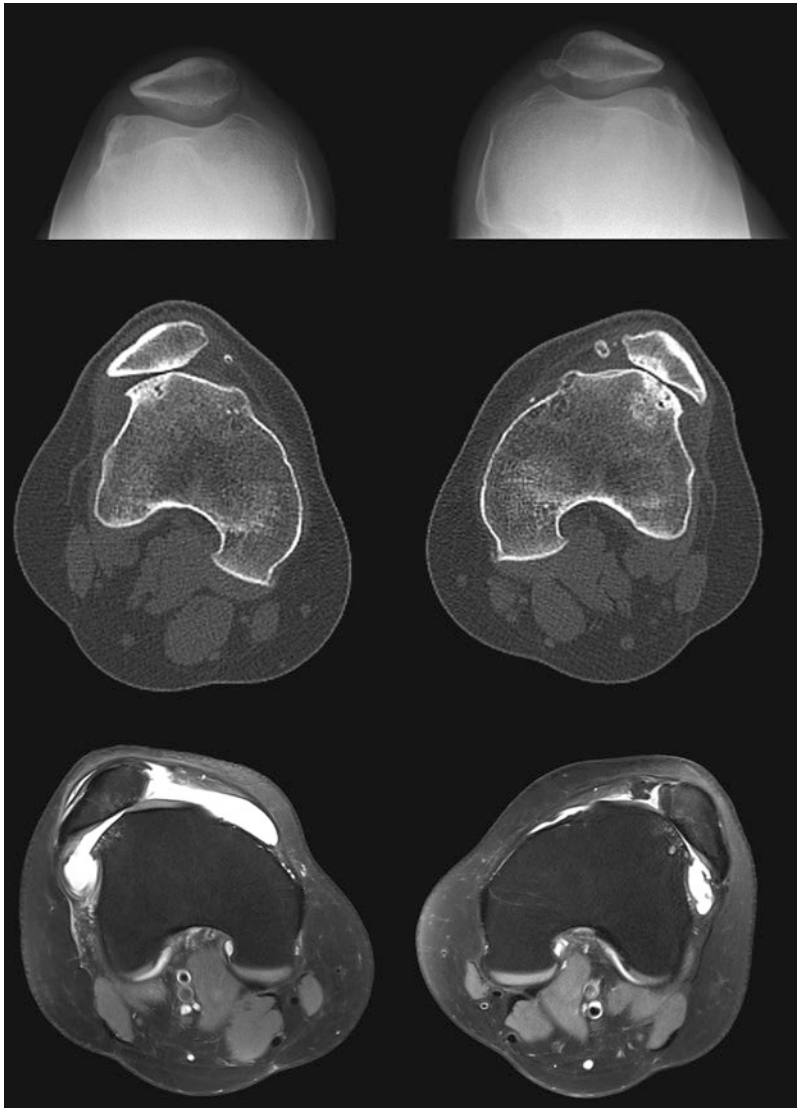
Conventional axial radiographs (*top*) show seemingly well-located patellae as the radiographs are obtained at a minimum of 30 degrees of flexion. In reality there is severe patellar instability which is unmasked when CT (*middle*) or
